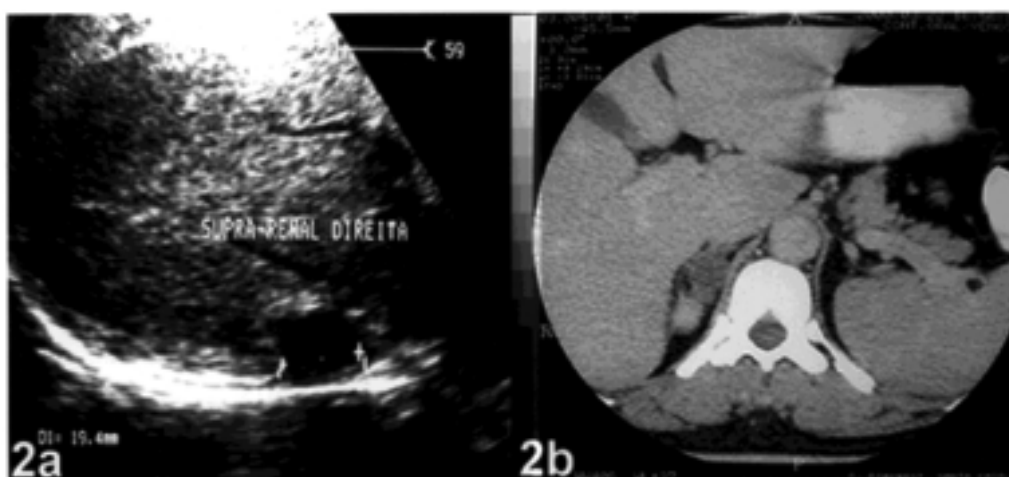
Abdominal US (2a) and CT scan (2b) of the right adrenal gland identifying the aldosterone-producing tumor.
